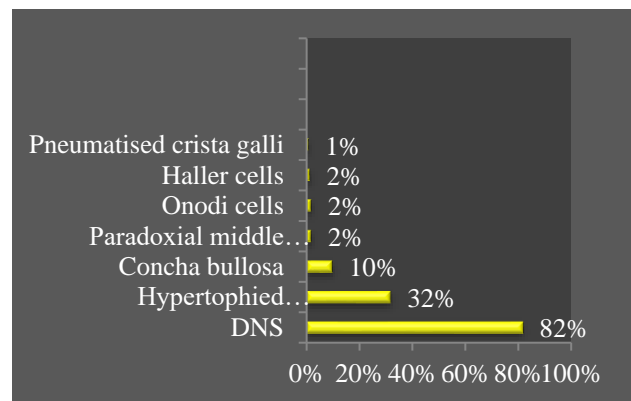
The different anatomical variations observed by CT study.
